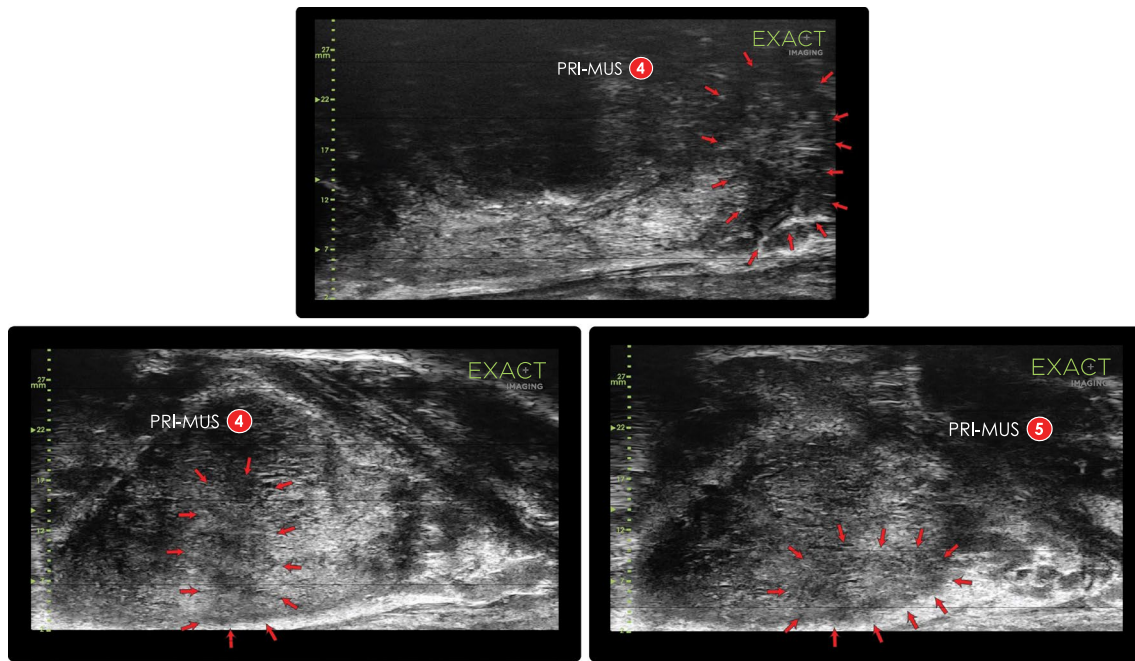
(Top) micro-ultrasound target (PRI-MUS 4) identified in left lobe of the prostate near the apex, characterized with smudgy and hypoechoic features, and confirmed by pathology as a Gleason Sum 7/Grade Group 2 cancer. The patient had a PSA of 4.05 ng/mL, a previous negative biopsy, a negative MRI, and all systematic biopsy samples were benign. (Bottom) micro-ultrasound targets for a patient with PSA 4.8 ng/mL with negative MRI. (Left) PRI-MUS 4 identified
